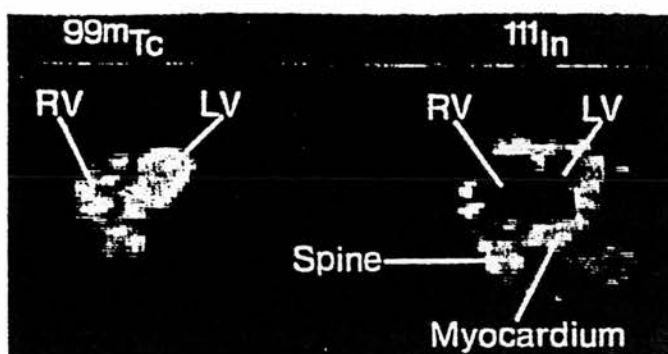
Simultaneous single photon emission computed tomographic images in the transverse plane. The ^{99m}Tc image shows blood pool in the left and right ventricle. The corresponding ^{111}In image shows extensive uptake within the myocardium of both ventricles.
